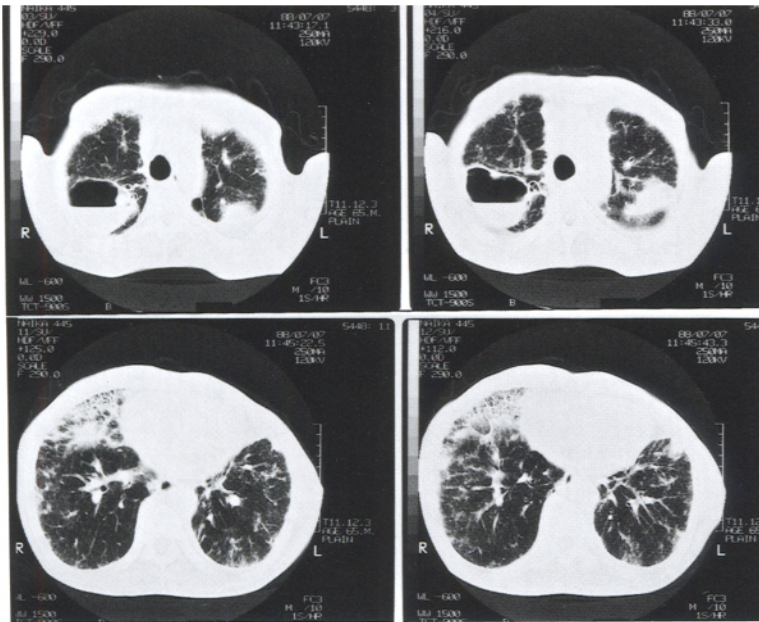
CT images demonstrate a large cavity with fluid level in the right upper lung zone. In the lower zones, ground-glass and reticular opacities are noted bilaterally, suggesting diffuse interstitial fibrosis
